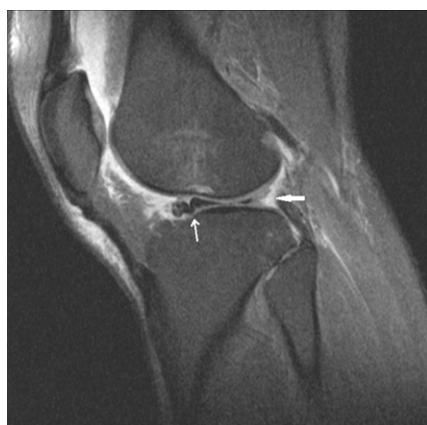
Sagittal T2-weighted MR image through the lateral compartment shows the bucket-handle fragment of the lateral meniscal tear (thin white arrow), posterior to the anterior horn, producing the flipped meniscus sign. Absence of the posterior horn was also noted (thick white arrow).
